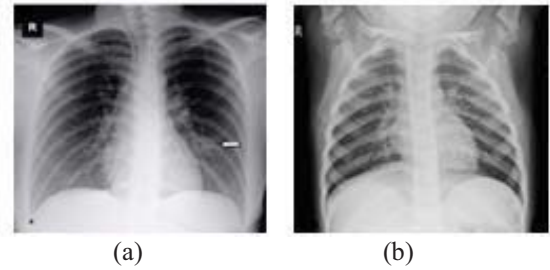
Sample x-ray of (a) non-COVID patient (b) COVID infected person
